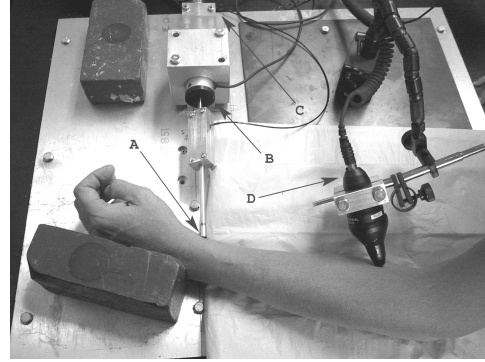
A subject's arm is shown positioned on the relaxoscope platform. The artificial pulse is applied by the force-sensing actuator stem tip at (A). The stem is driven by linear motor (B) and actuator displacement is measured using linear variable differential transformer (C). Induced flow velocities are recorded using Doppler stethoscope (D).
